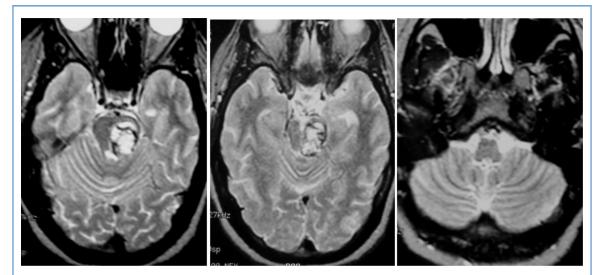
Magnetic resonance imaging scan from July 1992, 1 month after radiosurgery, demonstrating marked enlargement of the cavernous angioma of the brainstem when she was experiencing acute, new neurological deficits after the procedure.
